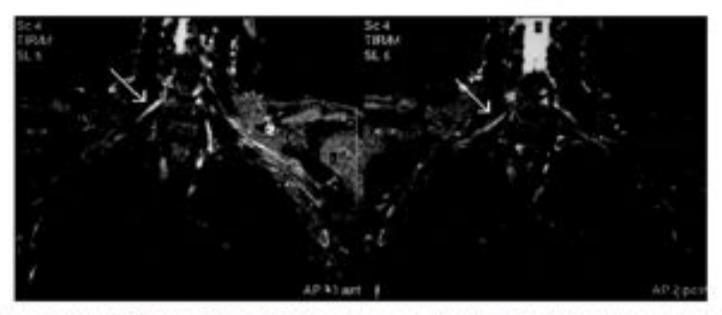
I T2-weighted non-contrast MRI scan of the brachial plexus, showing a thickened and slightly hyperintense middle trunk on the right.
